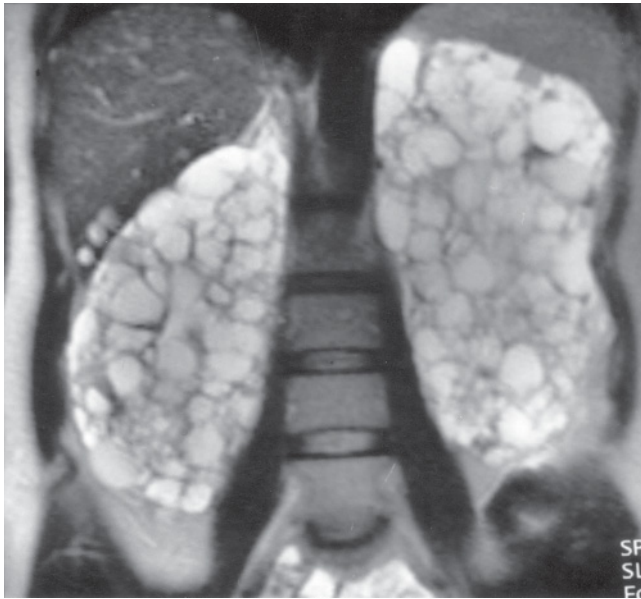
(Continued) single-shot echo-train spin-echo (h) and coronal T1-weighted postgadolinium hepatic venous-phase (i) and interstitial-phase (j) fat-suppressed 3D-GE images demonstrate autosomal dominant polycystic kidney disease in the early stage of development in another patient. Multiple cysts that have various signal intensities on T2- and T1-weighted images are detected in both kidneys. Various signal intensities of the cysts reflect various stages of blood products developing secondary to hemorrhage or proteinaceous material. One of these cysts with intermediate signal on both T2-weighted and T1-weighted images is shown with an arrow (b-j).
